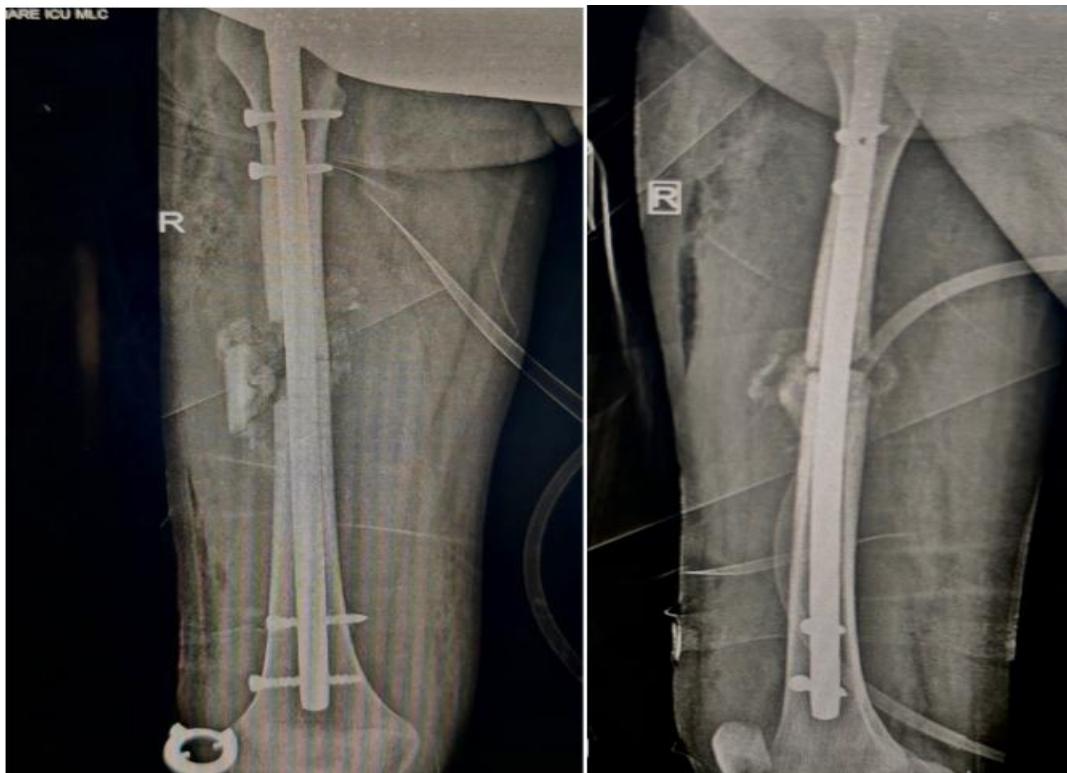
Postoperative radiographs of a femoral shaft fracture in pregnancy. Postoperative anteroposterior and lateral radiographs demonstrating fixation with a locked intramedullary femoral nail, with improved alignment and appropriate positioning of the implant
